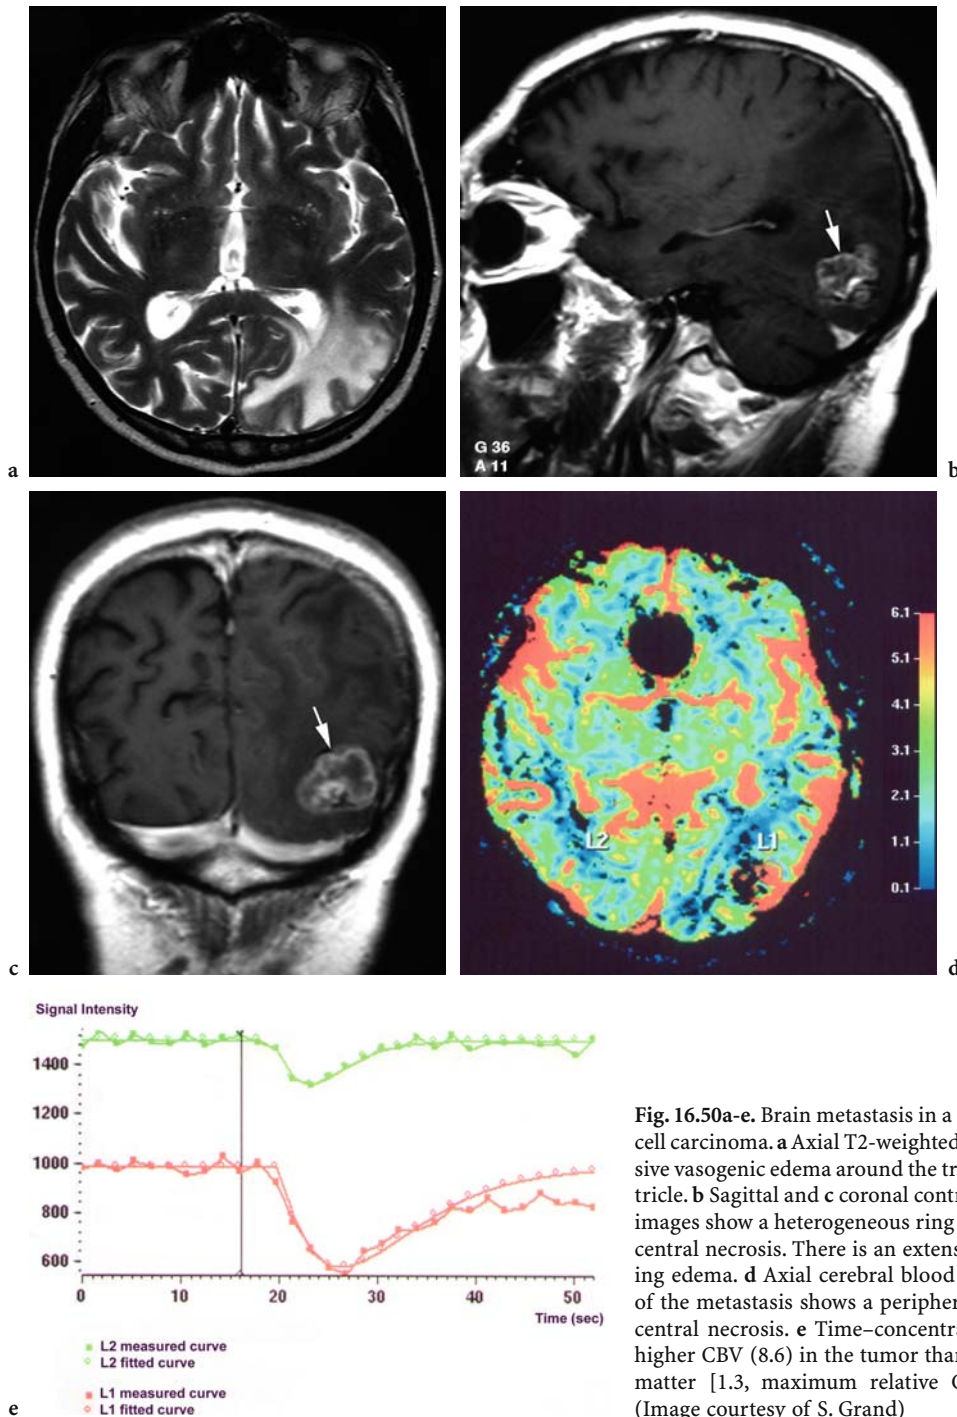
Brain metastasis in a 68-year-old man with renal cell carcinoma. a Axial T2-weighted MR image shows an extensive vasogenic edema around the trigone of the left lateral ventricle. b Sagittal and c coronal contrast-enhanced T1-weighted images show a heterogeneous ring enhancement (*arrow*) with central necrosis. There is an extensive hypointense surrounding edema. d Axial cerebral blood volume (CBV) map image of the metastasis shows a peripheral hypervascular ring with central necrosis. e Time-concentration curves show a much higher CBV (8.6) in the tumor than in the contralateral white matter [1.3, maximum relative CBV (rCBVmax) of 6.61]. (Image courtesy of S. Grand)
